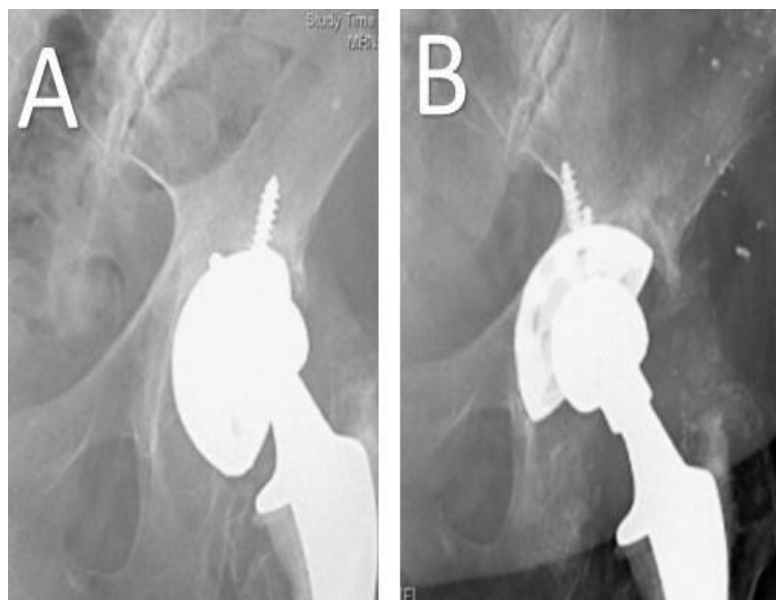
(A) A preoperative radiograph demonstrates a malpositioned cup with evidence of loosening clinically. (B) A postoperative x-ray after revision shows a medialized component beyond Kohler's line with adequate bone coverage ⁽²⁹⁾.
